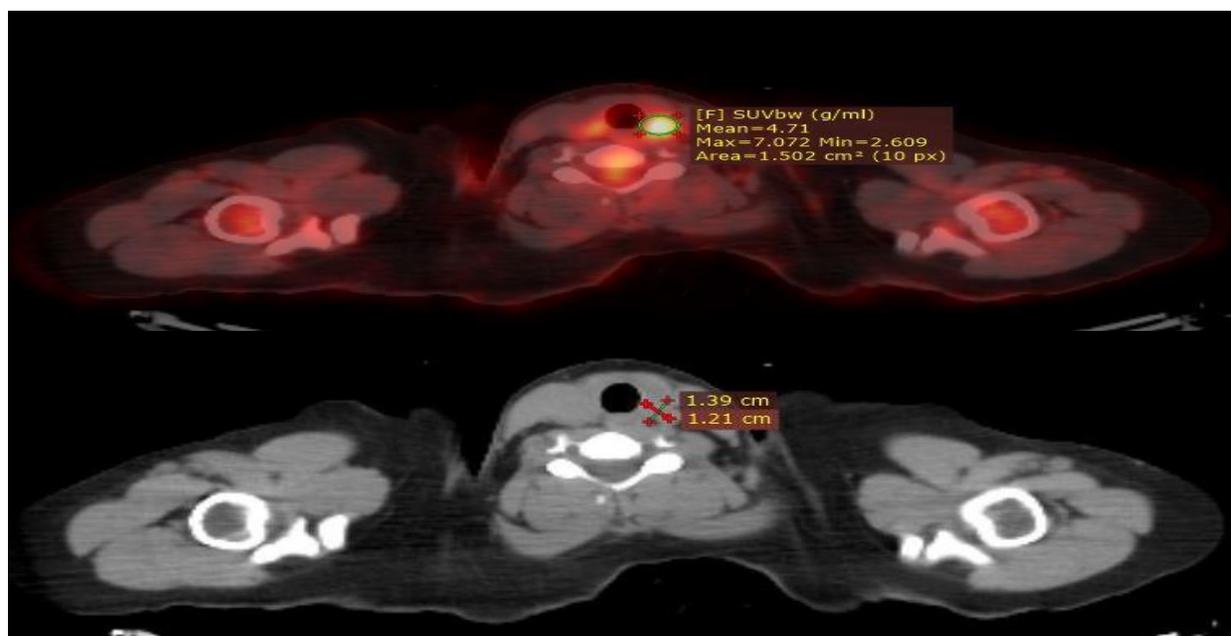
Initial pre-ablative PET/CT fused axial images and CT revealed FDG avid left thyroid operative bed nodule while the iodine scan did not show this nodule suggesting its malignant nature with dedifferentiation, then the patient underwent surgical consultation but refused and received RAI-131.
